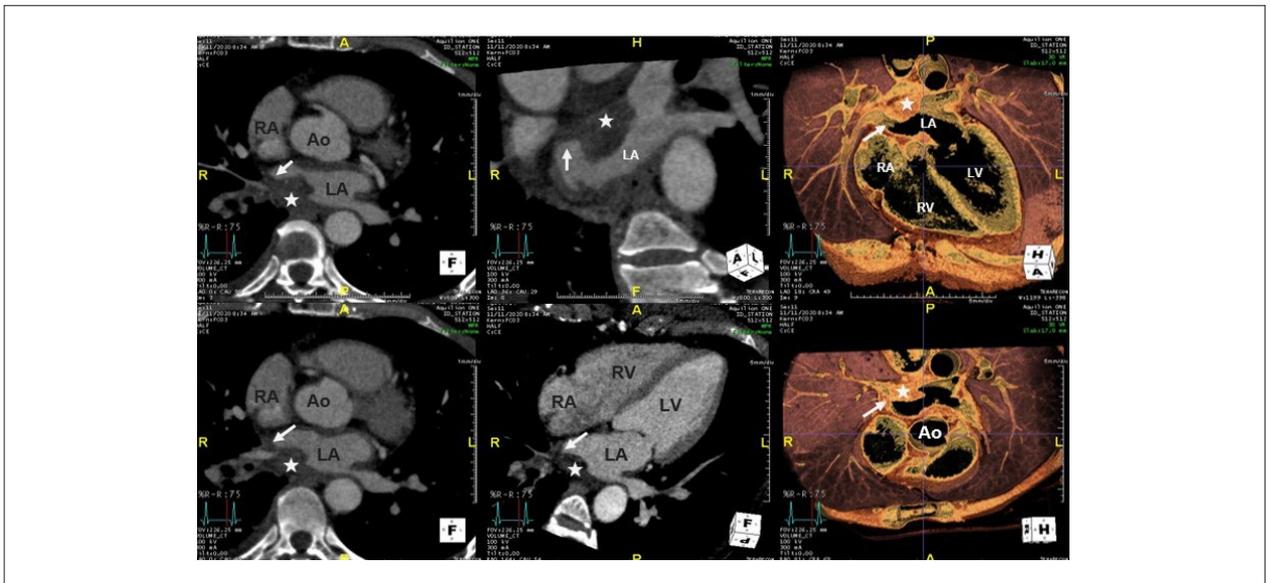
Cardiac computed tomography. A homogenous, hypodense, slightly irregular sessile mass (★), located in the posterior wall of the left atrium (LA), involving both ostia of the right pulmonary veins is depicted (arrows). Ao: Aorta; RA: Right atrium; RV: Right Ventricle; LV: Left Ventricle.
